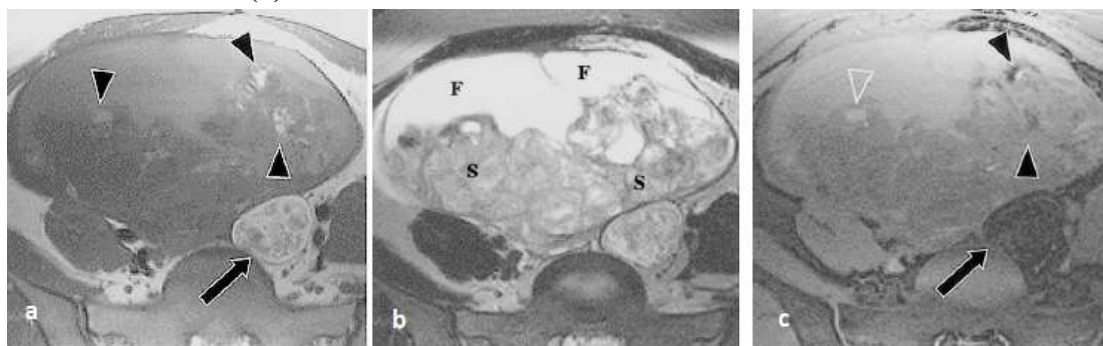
Immature teratoma associated with ipsilateral mature cystic teratoma in a 27-year-old woman. (a) Axial T1-WI shows a large mass of the left ovary with multiple high signal- intensity foci (arrowheads). A lesion with the typical appearance of a mature cystic teratoma lies adjacent to the mass (arrow). (b) Axial T2-WI shows the large fluid (F) and solid (S) components of the mass. (c) Fat-suppressed T1-weighted FSGE shows that some of the high-signal-intensity foci in a are hemorrhagic and retain their high signal intensity (open arrowhead), whereas others represent foci of fat (solid arrowheads). The ipsilateral mature cystic teratoma demonstrates suppression of the signal of the cyst contents (arrow) (12).
